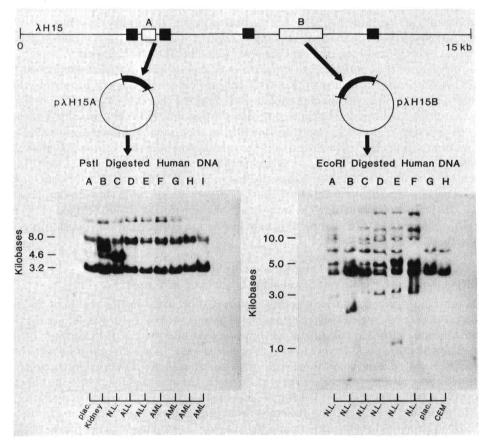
DNA rearrangement in normal and leukemic individuals. The dark boxes on the human inset of  $\lambda$ H15 represent Alu repeat sequences flanking the DNA fragment present in subclone  $p\lambda$ H15A. Ten micrograms of human DNA was digested with Pst I (left side) or Eco RI (right side), electrophoresed through 1% agarose gels, and transferred to nitrocellulose. The resulting blots were hybridized with labeled  $p\lambda$ H15A and  $p\lambda$ H15B, respectively, and the hybrids were exposed to x-ray film. AML, acute myelogenous leukemia; N.L., normal leukocytes. Reprinted with permission from Calabretta et al. (*Nature* 295:219–225, 1982).
